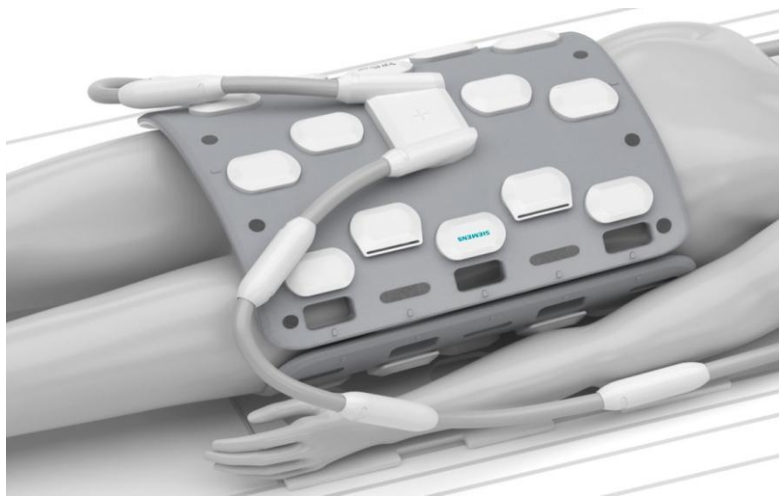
MRI abdomen coil.
